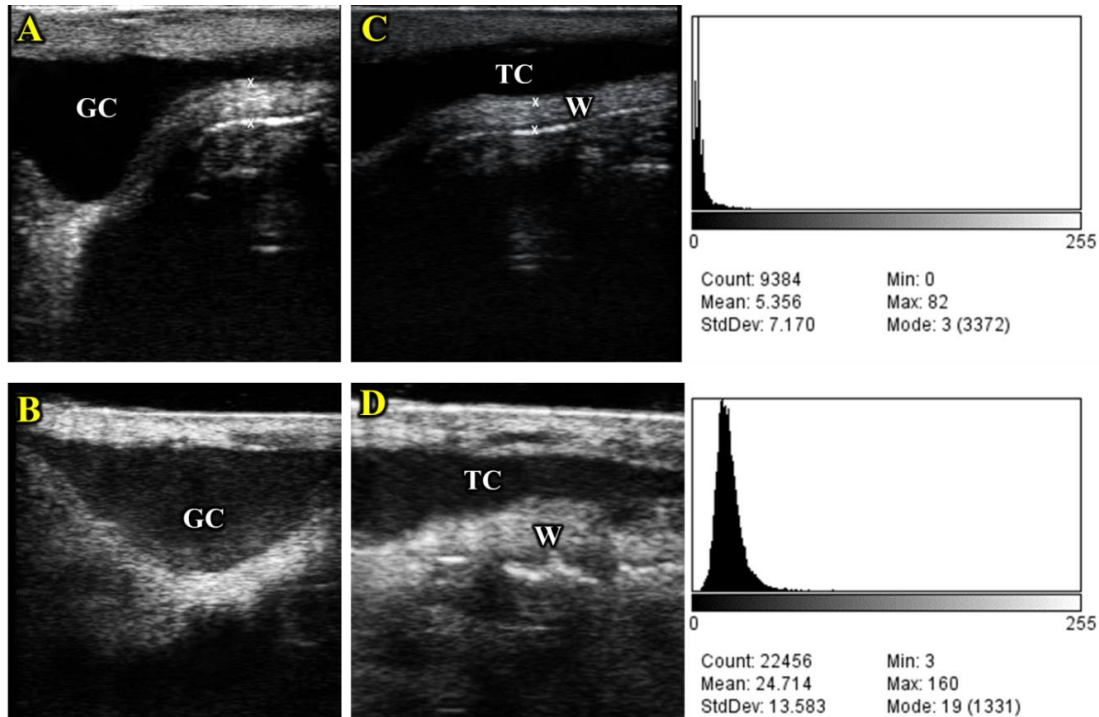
Ultrasonographic examination of mammary gland cistern and teat cistern and the corresponding gray scale histogram analysis of their milk contents in normal (A & C) and in subclinical mastitis (B & D). Showing gland cistern (GC), teat cistern (TC) and teat wall (T).
